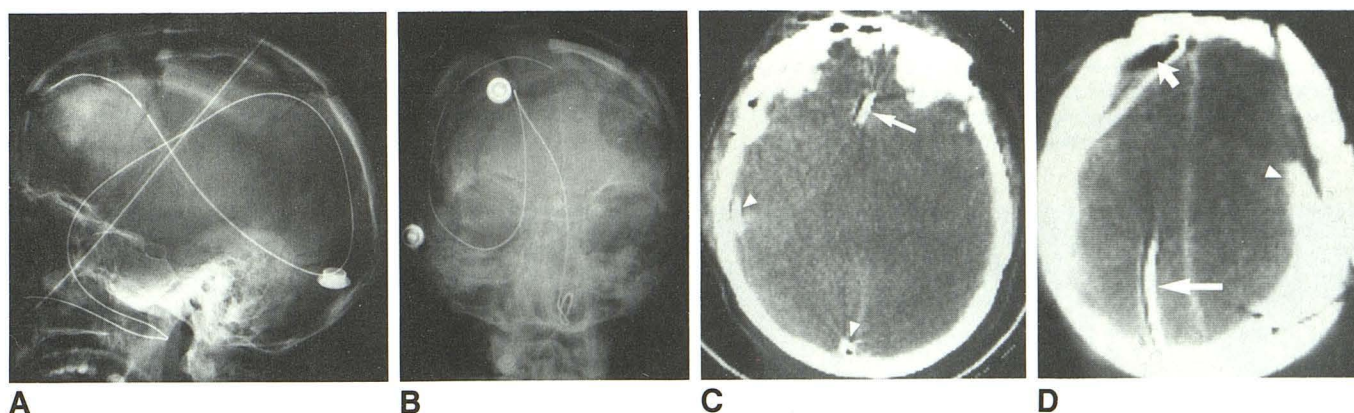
A, Lateral radiograph of skull shows extensive comminuted fractures and a large depressed fracture fragment in left parietal region. Fracture lines extend nearly to base of skull with opacification of sphenoid sinus. Nasogastric tube, kinked on itself in nasopharynx, extends through floor of anterior cranial fossa.
